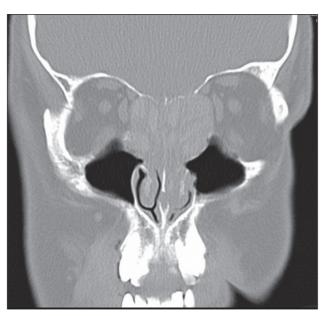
Coronal CT sinus demonstrating erosion of lamina papyracea and skull base
